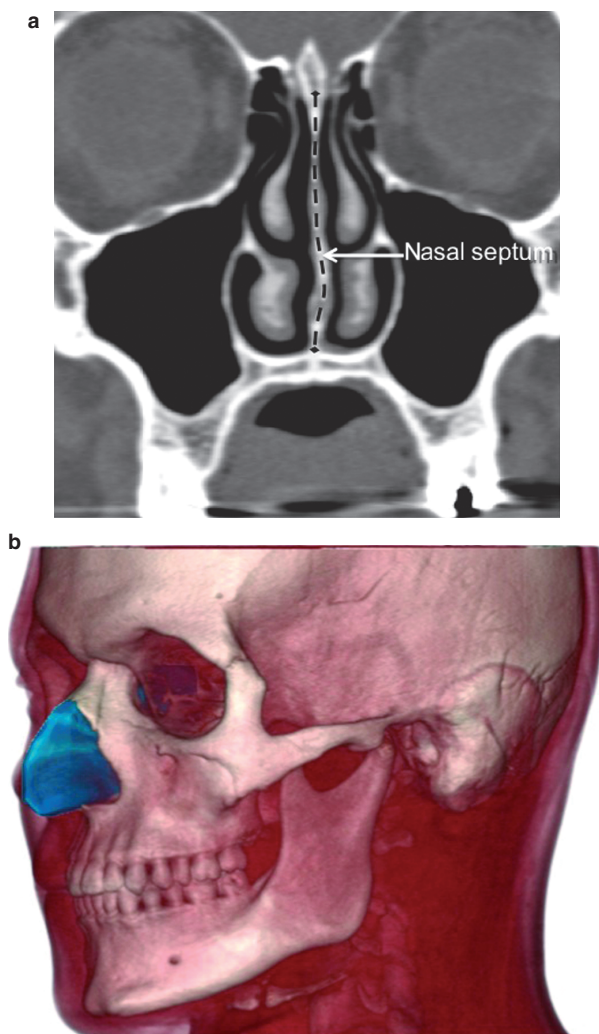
(a) Volumetric measurements of the nasal septum were calculated by manually segmenting the nasal septum using coronal computed tomography slices through the external nose and internal nasal capsule. (b) The segmented nasal septum was then reconstructed to calculate septal volume while maintaining a constant thickness.
